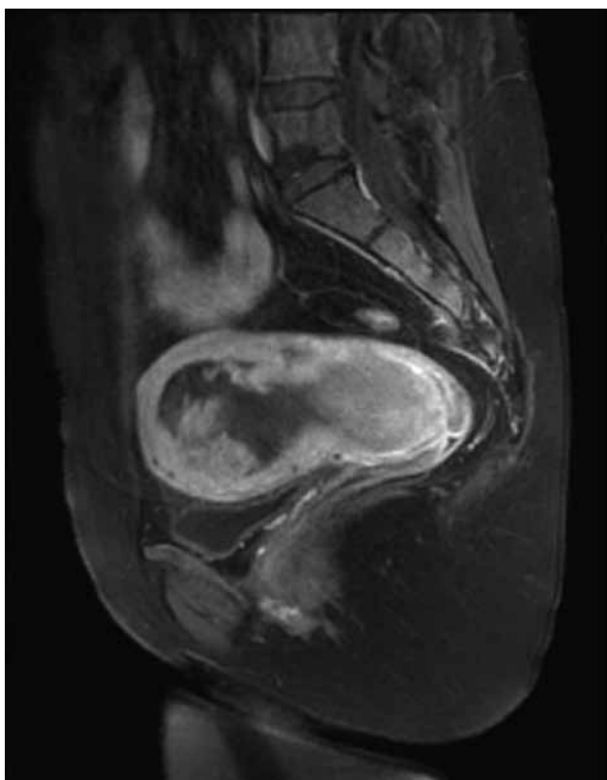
Magnetic resonance imaging of the lesser pelvis – longitudinal section
